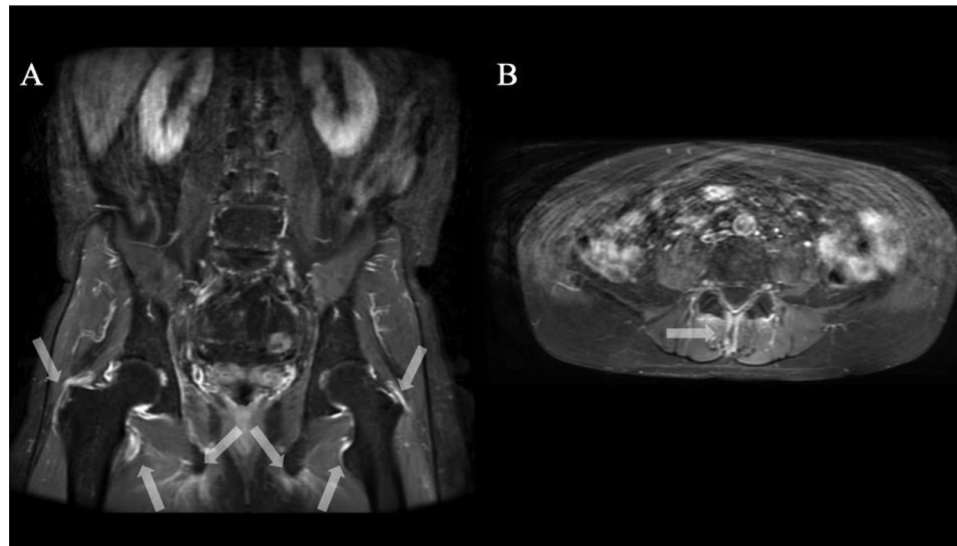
(A) Coronal postcontrast T1-weighted imaging revealed a high signal in the greater and lesser trochanter and sciatic tuberosity (arrow). (B) T1-weighted imaging after contrast administration showed a contrast effect in the spinous process (arrow). These findings indicated enthesitis of the greater and lesser trochanter, sciatic tubercle and spinous process.
